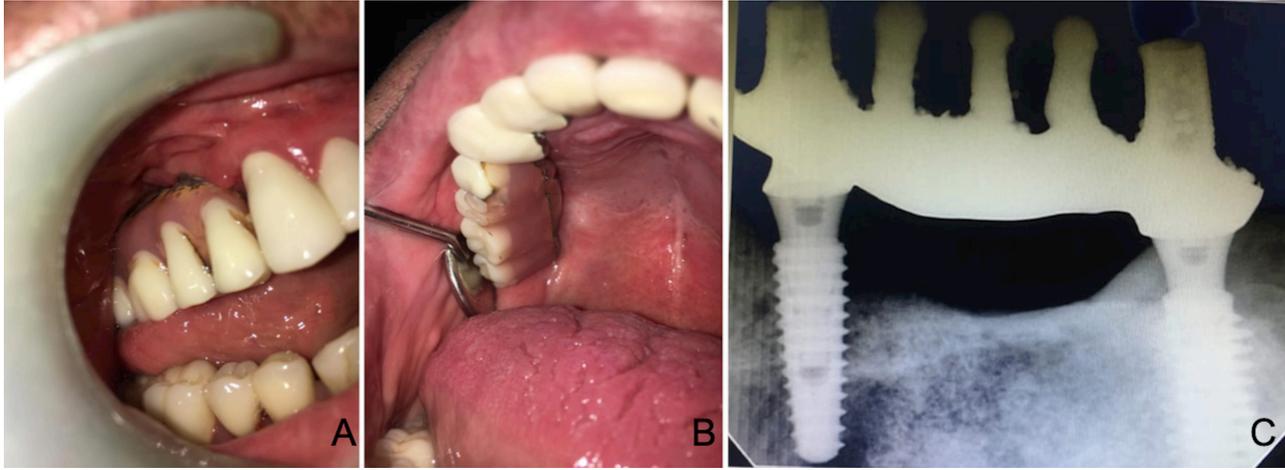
A and B intraoral view of the hybrid prosthesis at 5-year follow-up. C periapical radiographs at 5-year-follow-up
